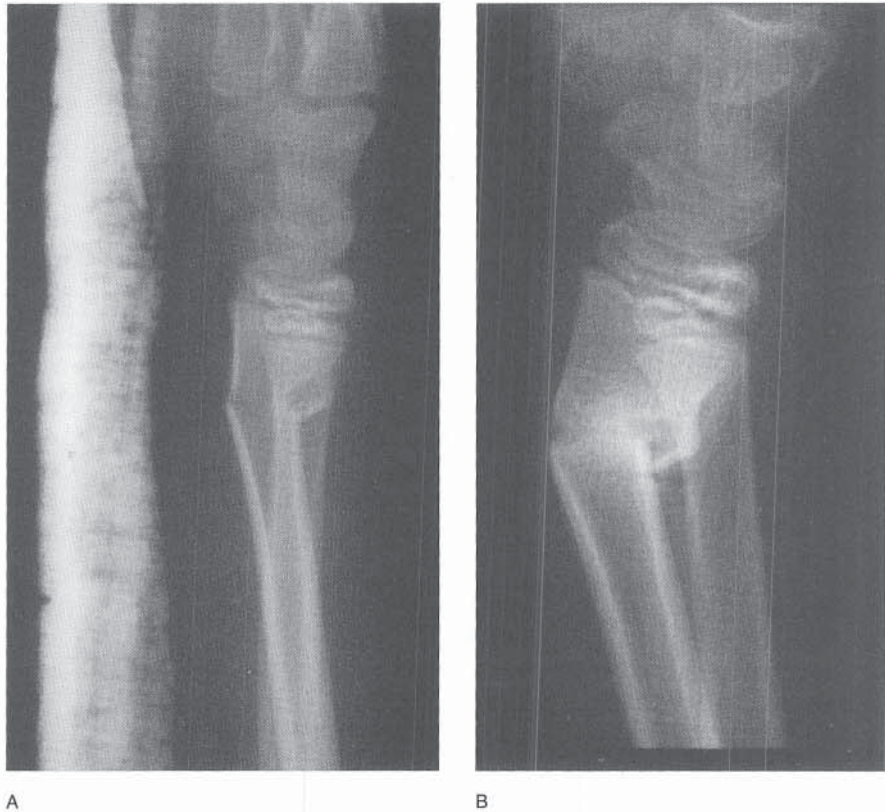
A, Lateral radiograph of a minimally displaced fracture of the distal radial metaphysis. Despite the buckled appearance, both cortices are completely fractured. This fracture was managed in a poorly molded volar splint. B, Radiograph obtained after removal of the volar splint, 4 weeks after the injury. Note the increased angulation.
